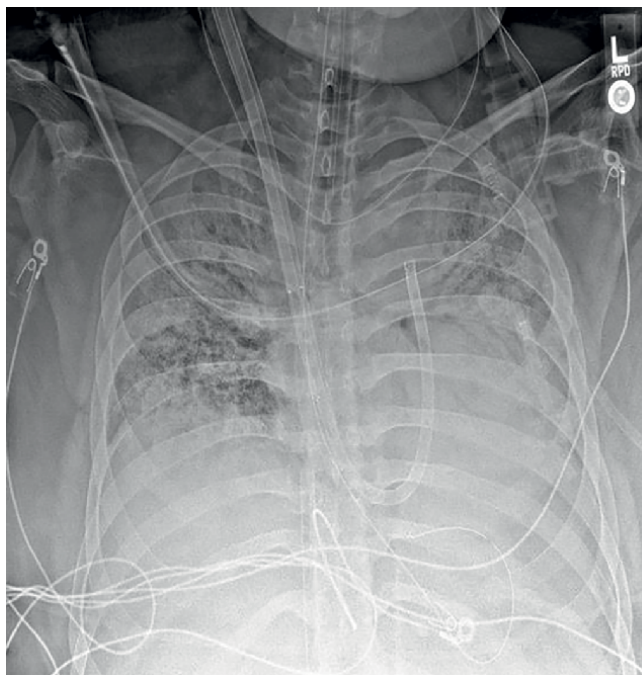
Chest X-ray of ProtekDuo® in V-P ECMO position with additional 25Fr drainage cannula with tip in right atrial/inferior vena cava junction through a femoral vein. Drainage through the femoral cannula and return through both lumens of the ProtekDuo® using a Y-piece after the oxygenator. Modified from: Maybauer MO et al. The ProtekDuo® as double lumen return cannula in V-VP ECMO configuration: A first-in-man method description. *Ann Card Anaesth.* 2022;25(2):217-9. With kind permission from *Ann Card Anaesth.*
